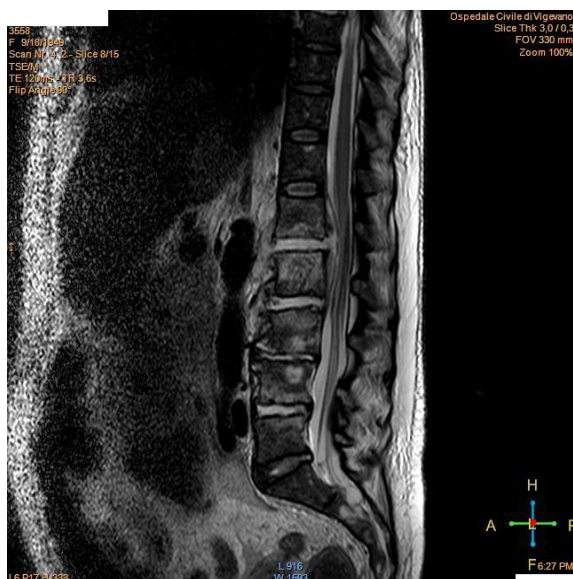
MRI sagittal cut showing hyperintense and inhomogeneous signal of lumbar tract during empiric antibiotic therapy.
